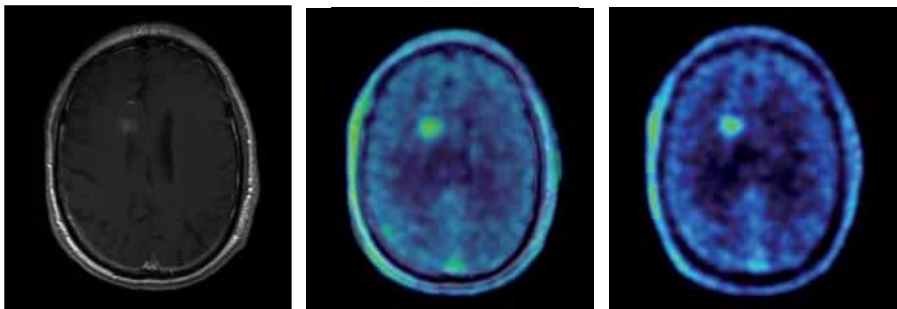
A: Pathological contrast enhancement in MRI imaging in a patient with suspected recurrence of glioblastoma multiforme
